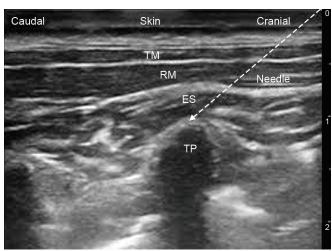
Sonography image showing erector spinae plane and needle pathway
